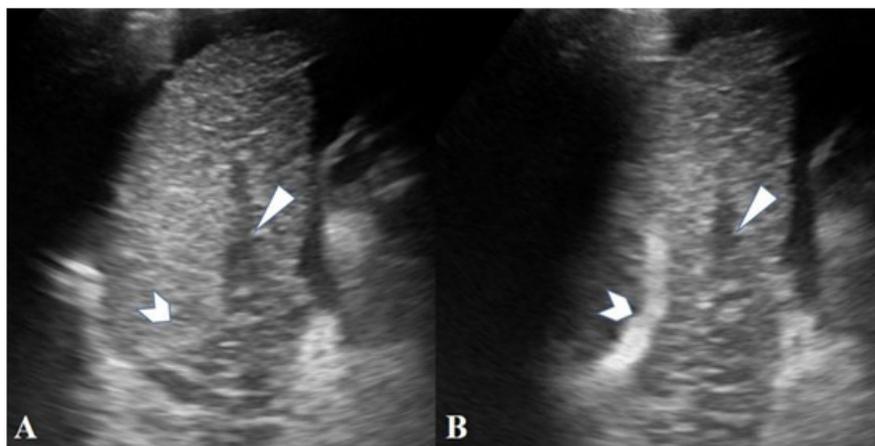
Display of hepatic vein before and after injection of saline in hepatic vein on sonogram. Initial sonogram showing proposed alignment of right portal vein (white triangle) with middle hepatic vein (white arrowhead) near its junction with IVC. (A) Sonogram before injection of saline. (B) Sonogram after injection of saline.
